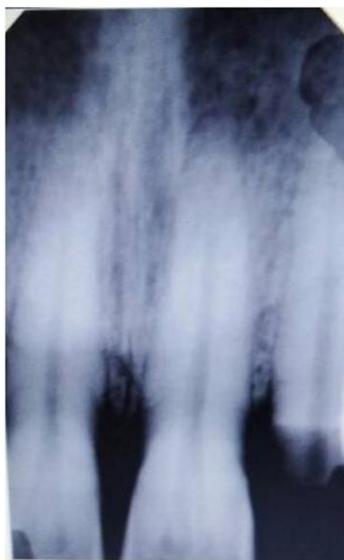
Periapical radiograph showing complete root development, no periapical pathology and absence of any bone fracture
